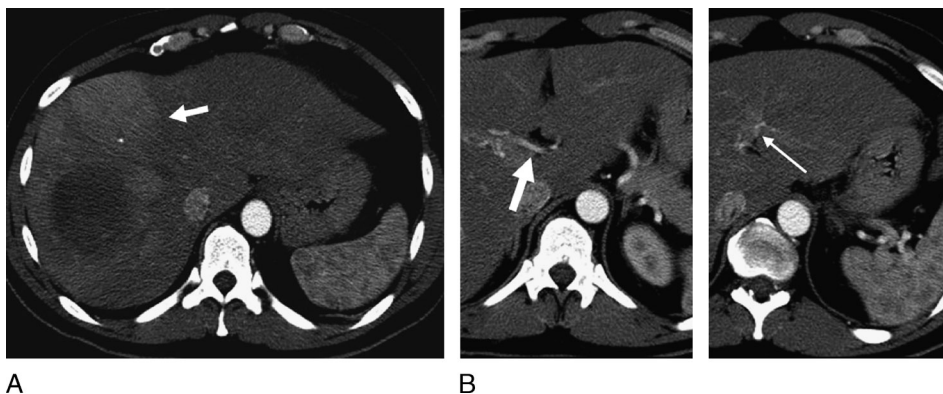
A 23-year-old man (number 8 of our series) with sump effect transient hepatic attenuation differences in the right liver lobe caused by pyogenic abscess. A, Artery phase CT scan reveals lobar transient parenchymal enhancement surrounding abscess endowed (arrow). B, Artery phase shows additional right primary artery branch (arrow) more conspicuous than the contralateral one (thin arrow).
